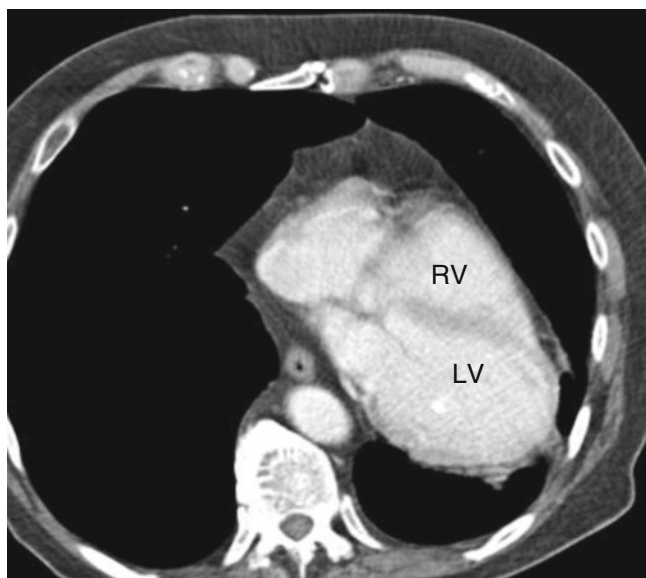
Complete absence of the pericardium. This is an axial contrast-enhanced computed tomogram demonstrating complete absence of the pericardium and marked displacement of the heart into the left hemithorax with the cardiac apex directed posteriorly. *RV* right ventricle, *LV* left ventricle
